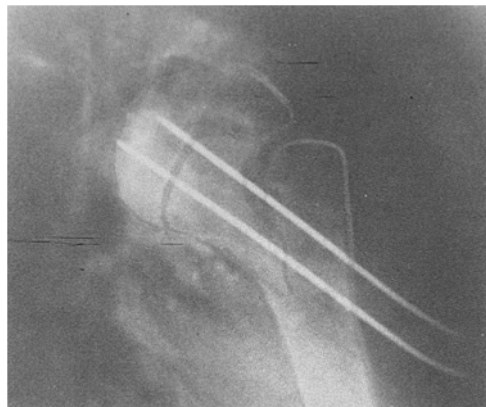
Postoperative radiograph with residual lateral and varus displacement of the distal fragment and two Kirschner wires in place
